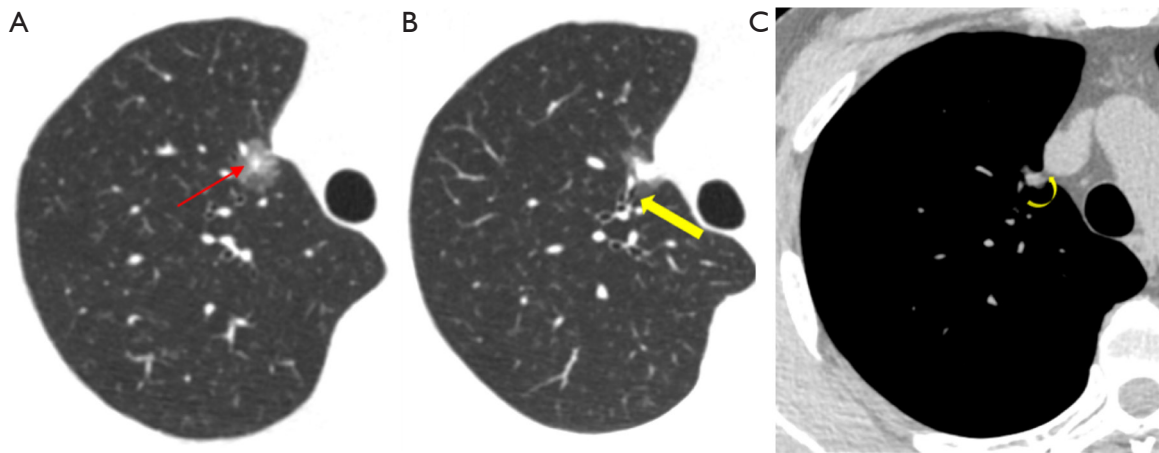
IAC. M, 48 y/o. A mGGN in the anterior superior lobe of the right lung was followed up for 847 days. (A-C) The interface was clear; the size was about 17 mm × 15 mm (the previous size was 16.0 mm × 15.0 mm); the solid component was about 10.0 mm × 9.0 mm (the previous size was about 6 mm × 8 mm); the CTR was 0.59; and the margin was lobulated. The density was not uneven; the CT value was -394.8 ± 191.0 HU (the previous CT value was -433.7 ± 197.6 HU); the tumor vascular sign was type IV (as indicated by the red arrow); the air bronchial sign was type I (as indicated by the yellow arrow); the pleural depression sign was type d (lower arcuate, as indicated by the curved arrow); and the VDT of the solid component was 678 days. IAC, invasive adenocarcinoma; M, male; y/o, years old; mGGN, mixed ground-glass nodule; CTR, consolidation tumor ratio; CT, computed tomography; HU, Hounsfield unit; VDT, volume doubling time.
